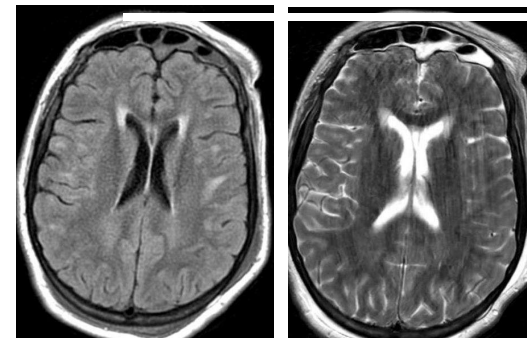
MRI T2 FLAIR 72 hours post-arrest with bilateral anterior encephalomalacia without evidence of diffuse anoxic injury.
